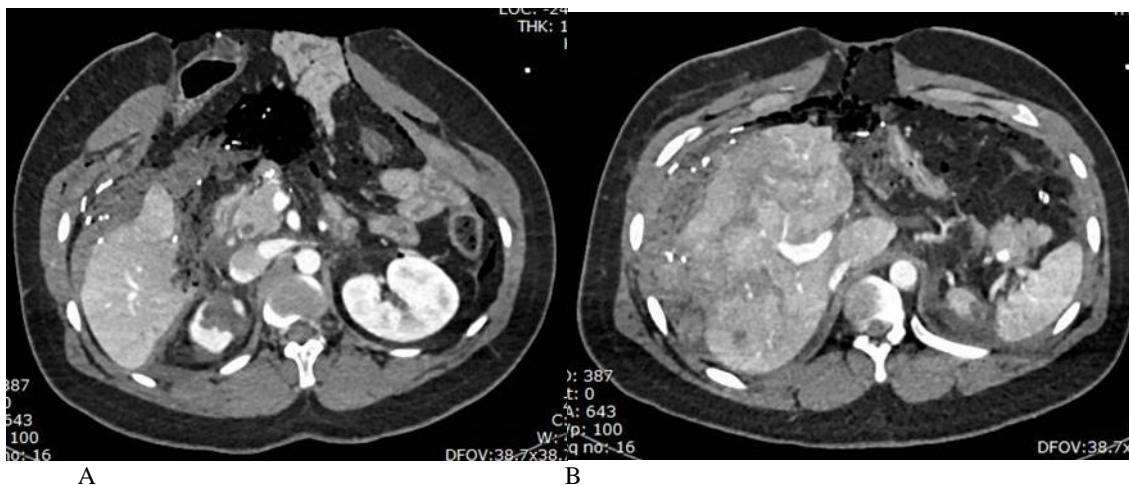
A, B: Axial enhanced CT scan of the abdomen shows liver lacerations seen as non-enhanced hypodensity, no evidence of contrast blush. Retroperitoneal and mesenteric fat stranding, abdominal wall defect and pneumoperitoneum. Perihepatic collection of 240.0 ml.
